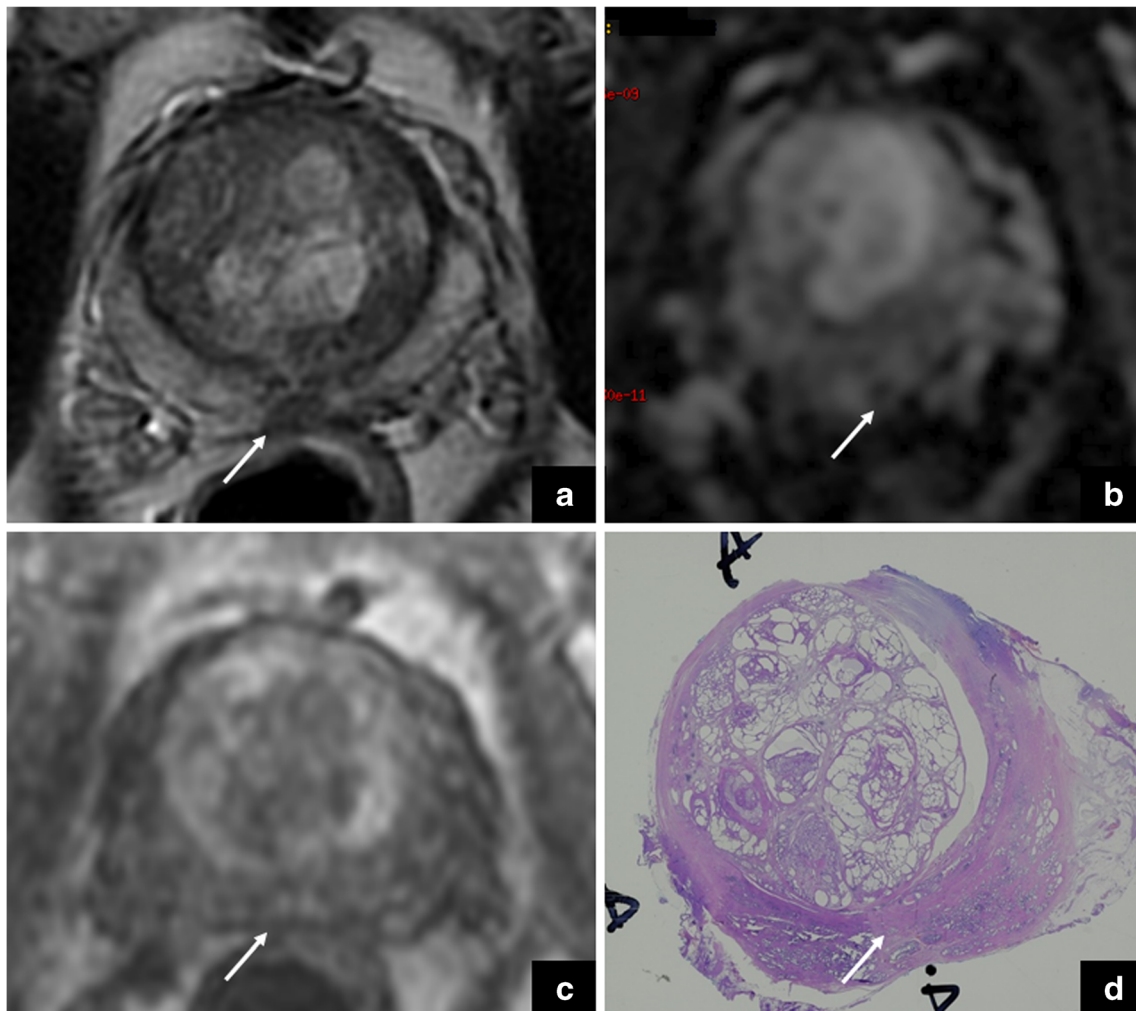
The arrows show a focal area with low-signal intensity on axial (a) and coronal (c) T2-weighted imaging, and restricted diffusion on DWI (b) at the prostate apex. The use of the coronal plane is very important to differentiate a pitfall (*teardrop*) from prostate cancer (*cancer in pitfall*)
